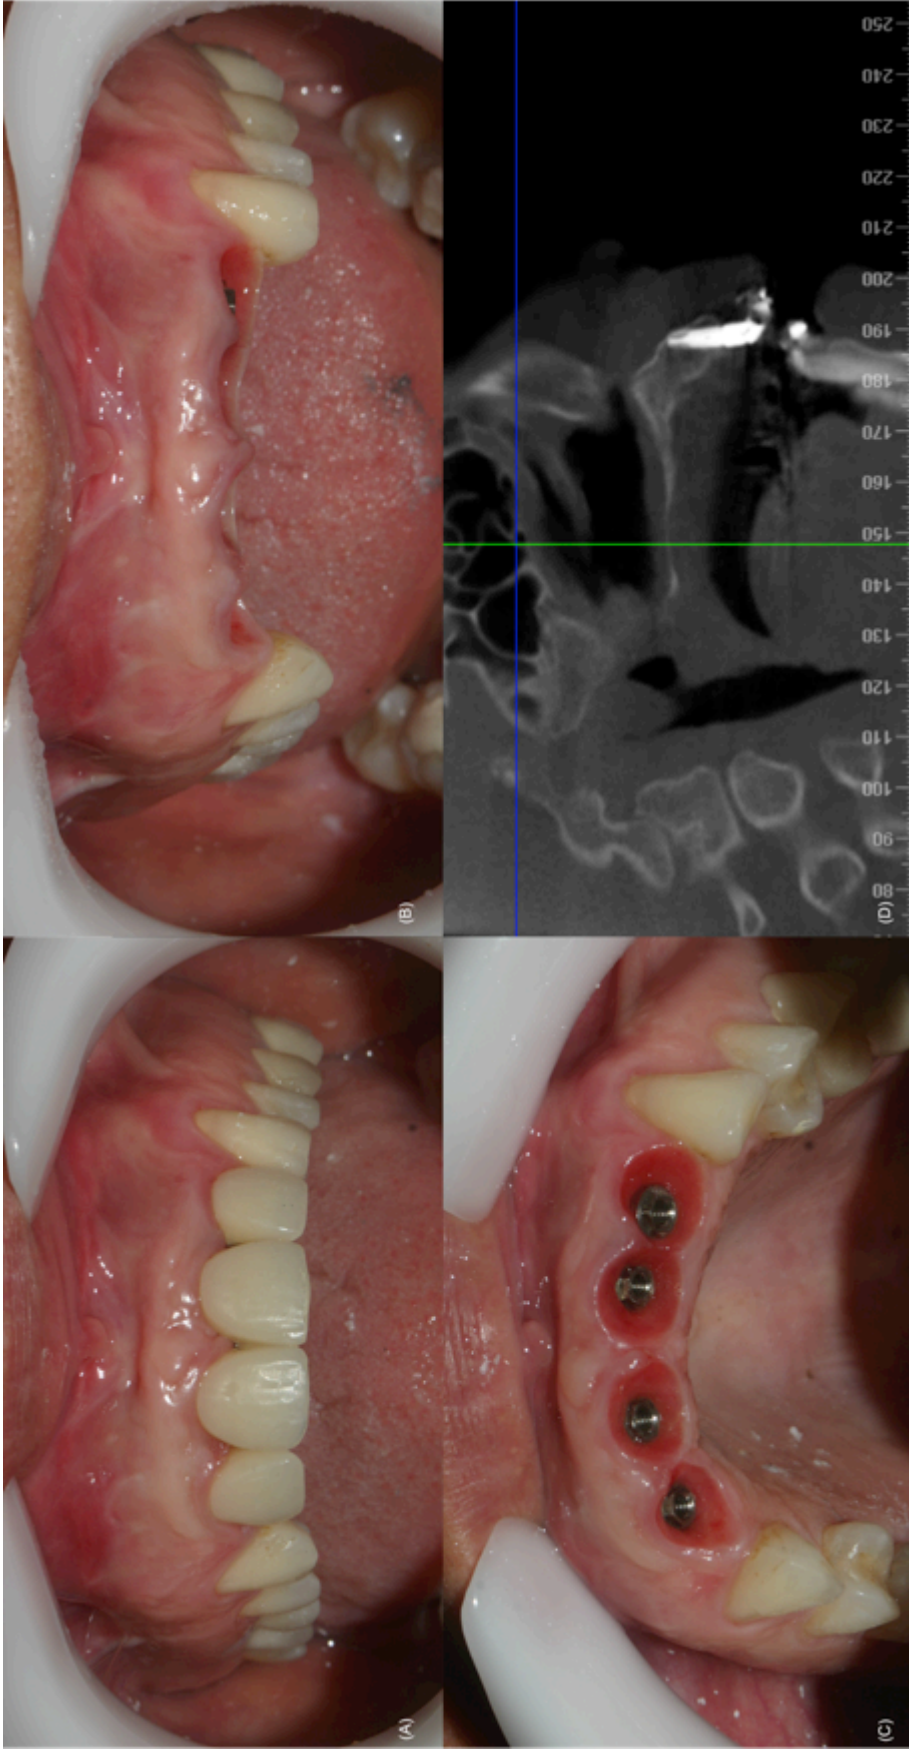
Clinical intraoral view of the final rehabilitation, showing considerable papilla formation, more than 2 mm of keratinized mucosa width and an improvement of esthetics (A, B and C). Sagittal slices of a CT in the implant in site of maxillary right central incisor showed bone formation in the region of the bone gap (D)
